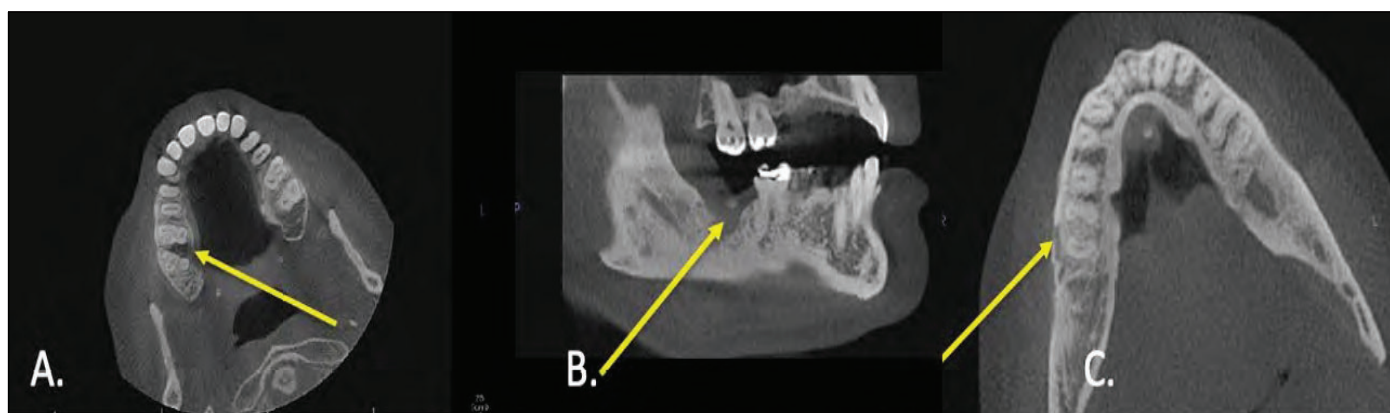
MRONJ site on CBCT. A. Mixed density on the palatal region of tooth #3 (ADA system). B. Mixed radiolucency and radiopacity in the region of missing tooth #18 (ADA system). C. Bone resorption and perforation of the cortex of the mandible in the region of tooth #29 to #31 (ADA system).
